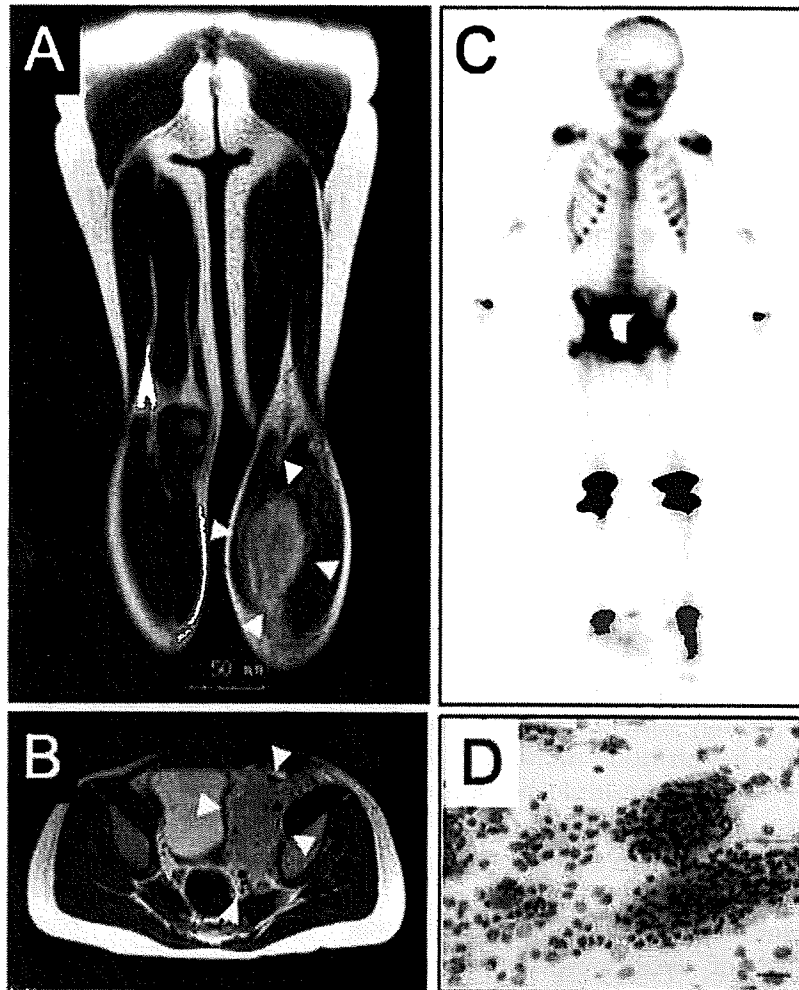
Studies at diagnosis. T2-weighted MRI images showing a mass on left leg (A, arrowheads) and metastatic swelling of para-aortic lymph nodes (B, arrowheads). (C) Scintigraphy of bone showed uptakes on right parietal, right 4th rib, and thoracic vertebrae. (D) Bone marrow aspiration showed aggregation of tumor cells.
